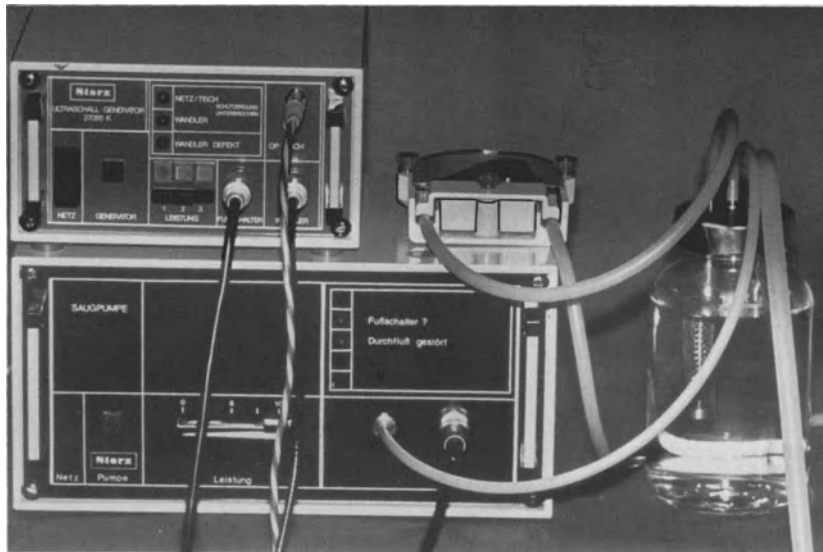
Ultrasound generator (*above*) with evacuator pump (*below*) and collecting trap (*right*)
